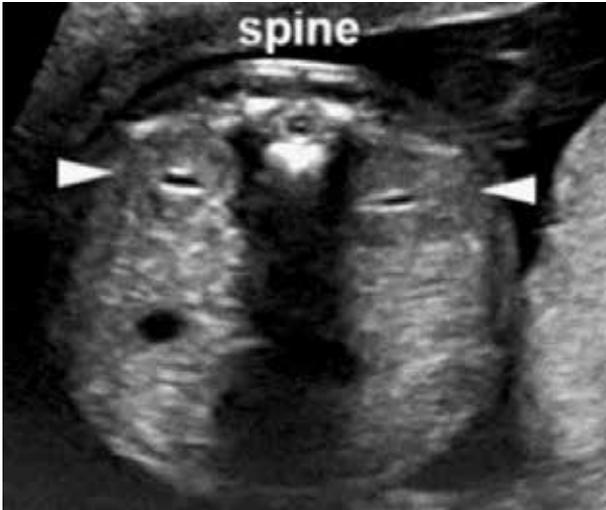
Ultrasound evaluation of fetal kidneys².
